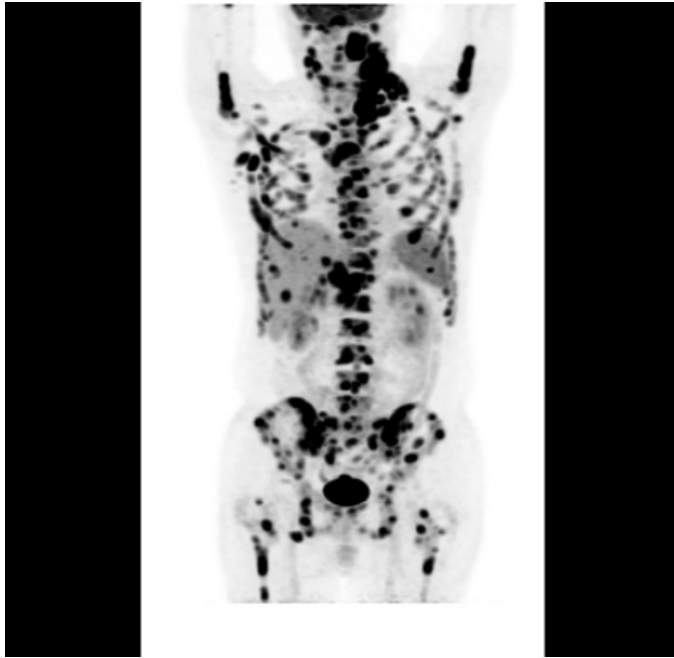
PET-CT imaging demonstrated widespread FDG uptake.
